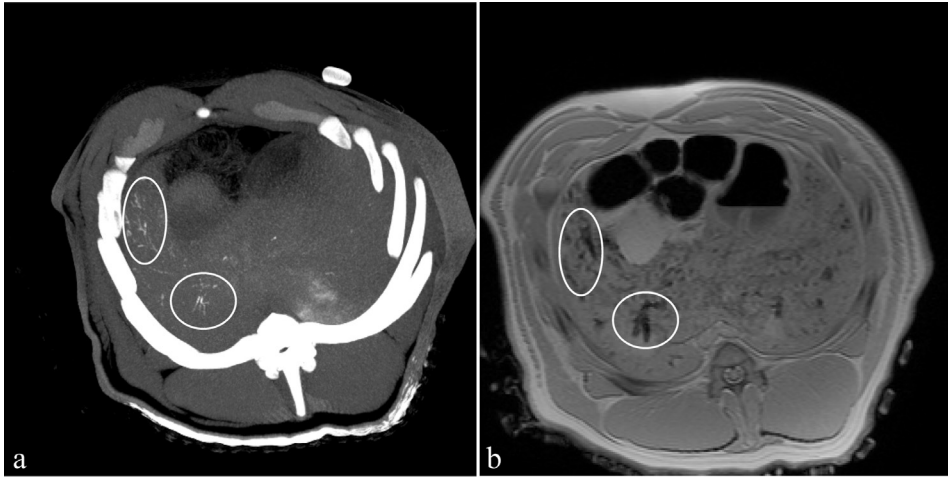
^{166}Ho -PLLA-MS visualized by CT maximum intensity projection (a), and by T_2 -weighted MRI (8-mm slice) (b). High concentrations are encircled
